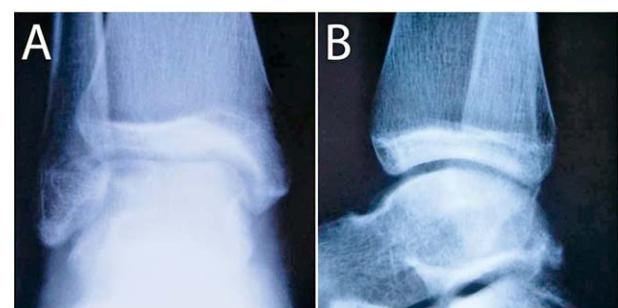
Postoperative plain radiographs of the right ankle in patient 1: plain radiographs of the right ankle in the anteroposterior (A) and lateral (B) views showing congruity of articular surface of the talar dome after arthroscopic microfracture.
